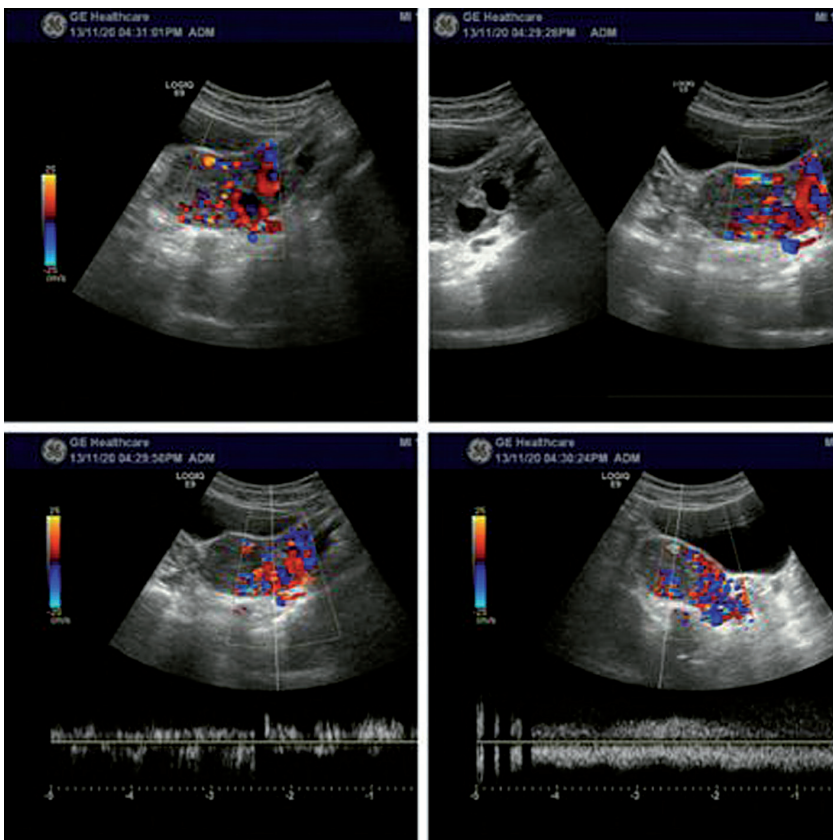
Color ultrasonography performed on November 21, 2013.
